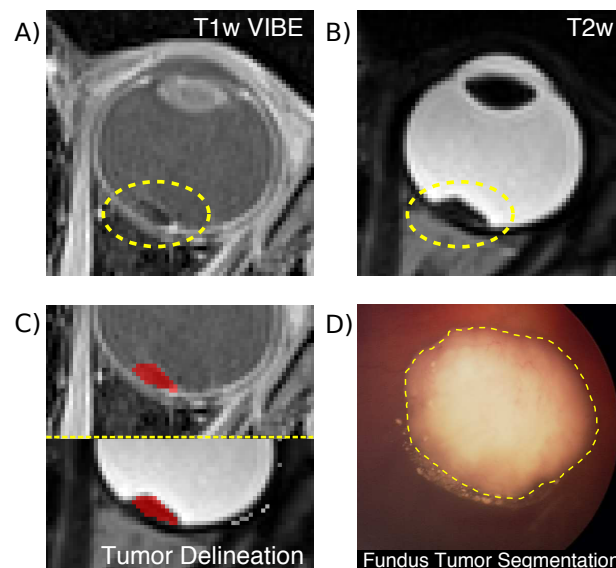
Multi-modal Imaging of Retinoblastomas (A)-(B) Detail of 3D T1w VIBE & T2w MRI (C) Delineation of eye tumor in both MRI sequences (D) Fundus of the eye and retinoblastoma manual segmentation (dotted line).
